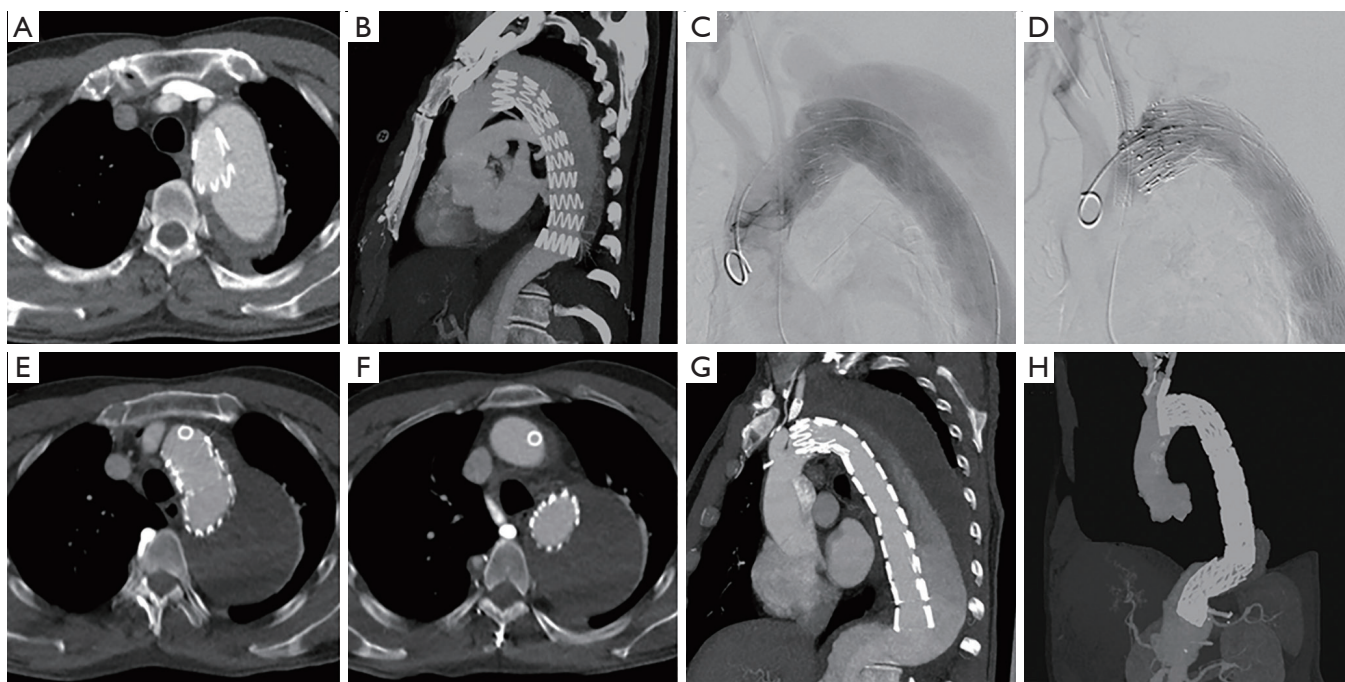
One patient was re-intervened for the increased false lumen after the previous TEVAR with the LCCA revascularized using the chimney stent. (A,B) Preoperative CTA showed a type Ia endoleak of an aortic dissection after initial TEVAR; (C) intraoperative angiogram; (D) the completion angiogram showed that the endoleak still existed after the placement of an aortic endograft and a chimney stent in LCCA; (E) follow-up CTA at 1 year showed the endoleak disappeared; (F,G) follow-up CTA at 5 years showed the patent chimney stent and disappeared proximal endoleak, but increased false lumen due to distal residual tears; (H) follow-up CTA after the placement of an additional aortic endograft to exclude the distal tear above the celiac orifice. No sign of the endoleak was showed. CTA, computed tomography angiogram; TEVAR, thoracic endovascular aortic repair; LCCA, left common carotid artery.
